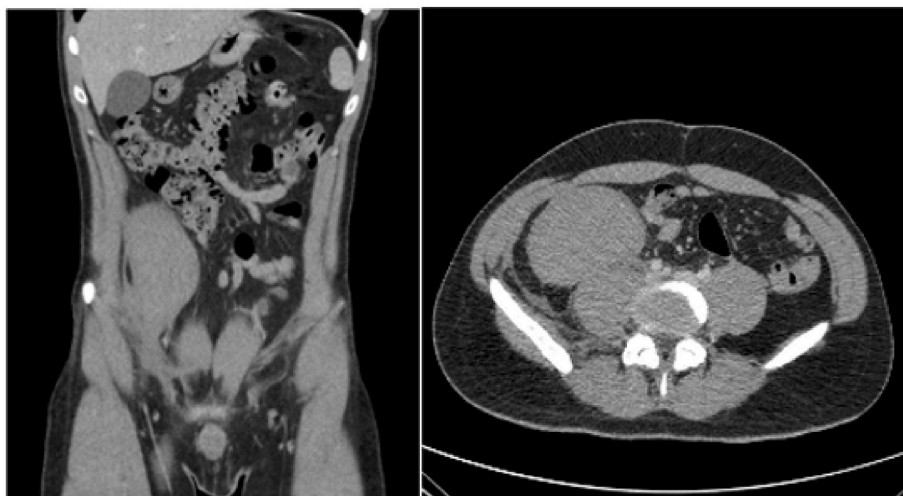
Admission CT scan.
